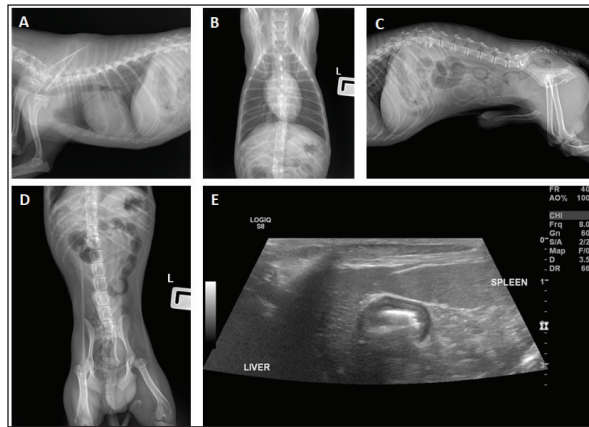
(A, B, C, D, E): (A, B) Lateral and ventrodorsal thoracic radiographs revealed no evidence of lung nodules and thoracic lymph node enlargement. (C, D) Lateral and ventrodorsal radiographs demonstrated no mass effect and the sign of abdominal lymph node enlargement. (E) B-mode liver and splenic ultrasonography showed normal parenchyma and homogeneously. No evidence of metastasis based on radiography and ultrasonography is detected.
